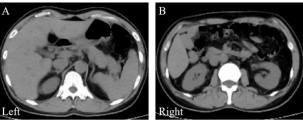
Abdominal CT scan. (A) Left figure shows the presence of diffuse enlarged lymph nodes in the hepatic hilum, greater omentum, and retroperitoneum; (B) right figure shows the presence of large infiltrative lesions surrounding both kidneys, bilateral thickening of therenal fascia.
